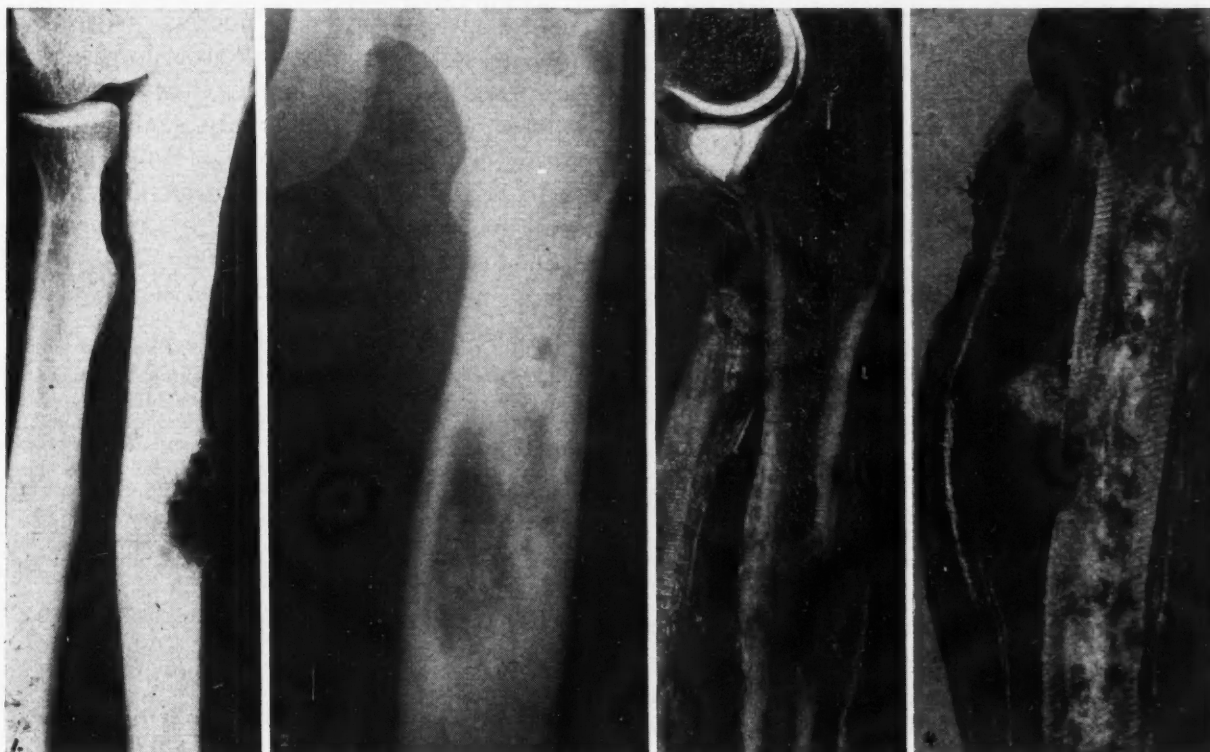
Radiographic appearance of the ulna tumour.
